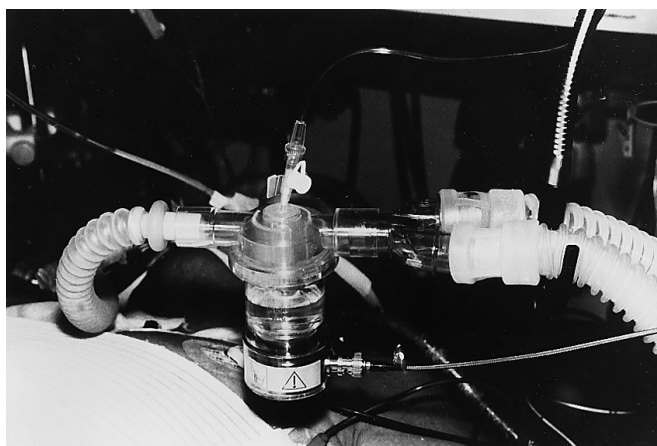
Aerosol delivery technique. PGI₂ buffer solution is delivered continuously to the chamber of the ultrasound nebulizer of the ventilator (Servo 300, Siemens) by an infusion pump. The dosage of PGI₂ aerosol delivered into the breathing circuit can be varied by the concentration of the added solution and by changing the ventilatory pattern (i.e. inspiratory flow, tidal and minute volume, ventilatory rate). Note the site of delivery close to the patient near the endotracheal tube
